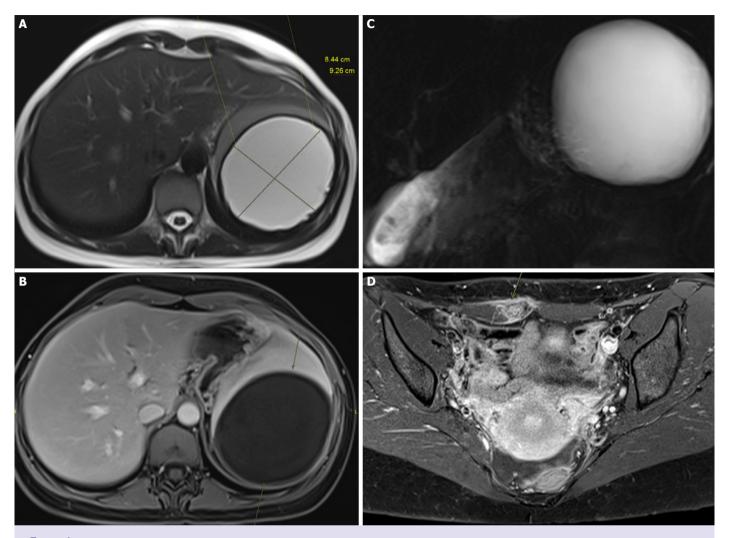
MRI: An 8.44×9.26 cm lesion with sharp borders within the spleen parenchyma which appears hypointense in axial T1 sequence (A) and hyperintense in coronal T2 sequence (B). T2 sequence revealed minimal border irregularity on the inner side of the cyst. MRI cystographic investigation revealed a cystic lesion in the spleen parenchyme (C). Post-contrast axial fat suppressed T1 investigation revealed a heterogenous lesion medial to the right rectus muscle (D).
